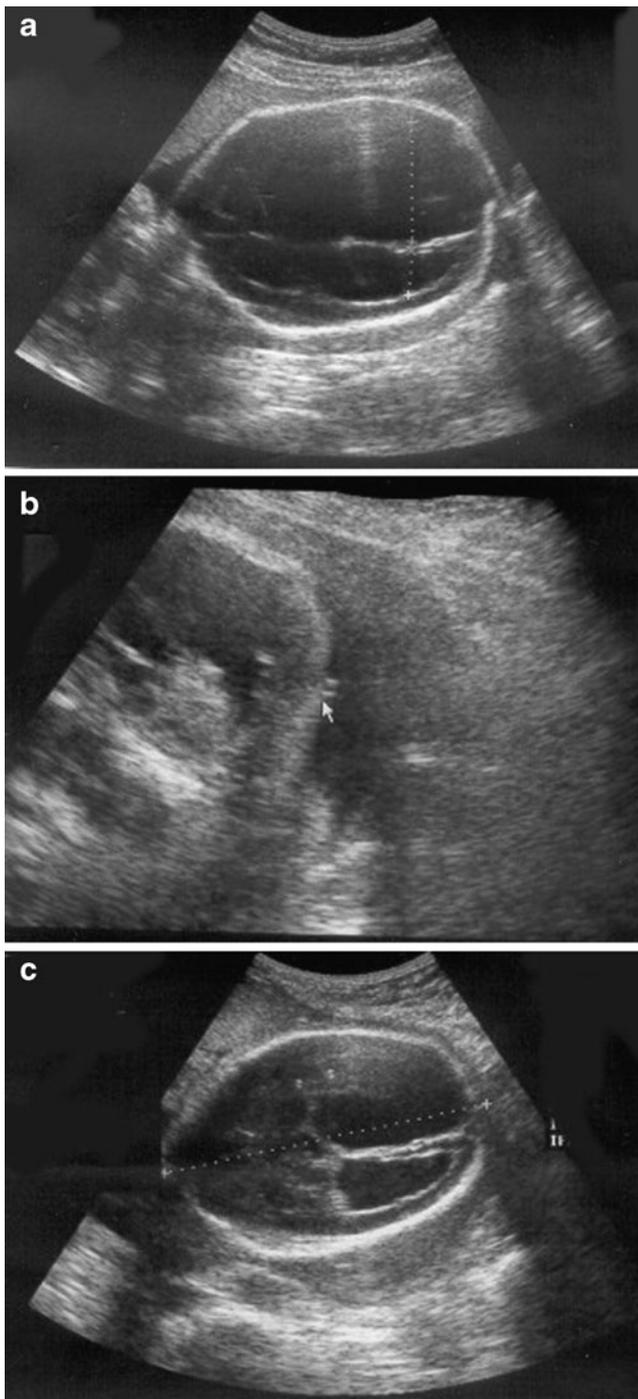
a Twenty-six-week gestation, ultrasound imaging showing voluminous ventriculomegaly. b Ventriculo-amniotic shunt placement (*arrow*). c Second postoperative day, decreased ventricular cavity
